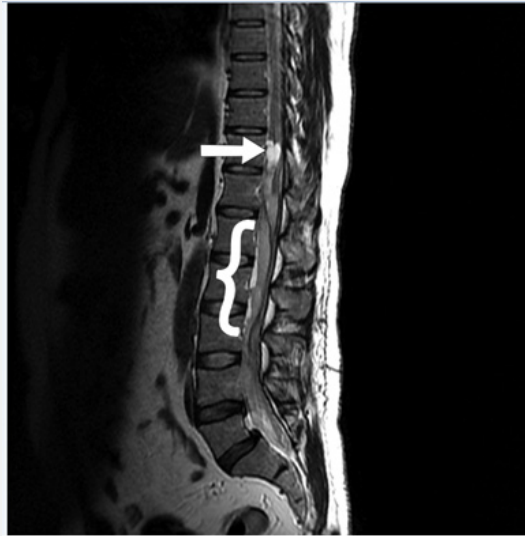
Lumbo-sacral spine MRI, sagittal T2 shows heterogeneous abnormal signal intensity with susceptibility artifact within the thecal sac and in the epidural/subdural space and the later one appears to be extending from T12 through L1 level and measuring approximately 9 mm in the maximum thickness resulting in displacement and compression of the cauda equina nerve roots and the conus medullaris which exhibit abnormal intramedullary T2 hyperintensity.
